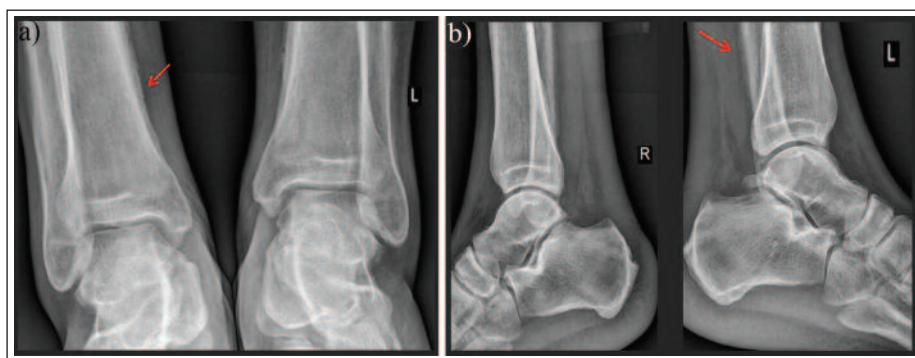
Ankle radiographs: a) AP and b) LL view
